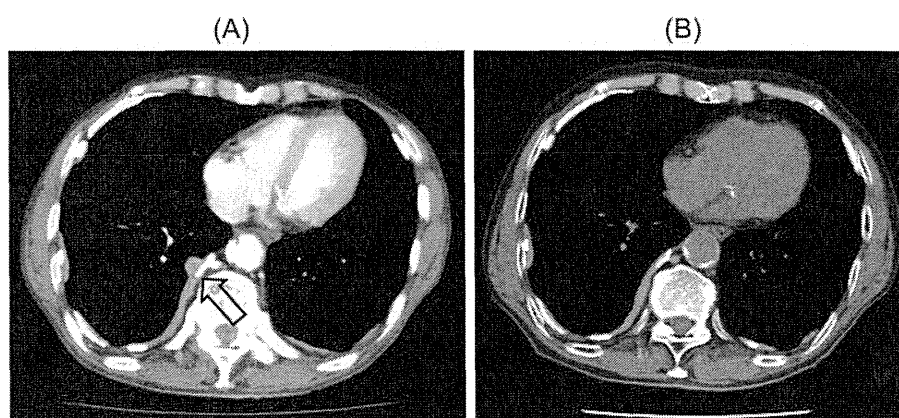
(A) Chest CT at initial presentation revealed neoplastic thickening of the right pleura. (B) The neoplastic lesion was not detected in the CT scan 6 months prior.
